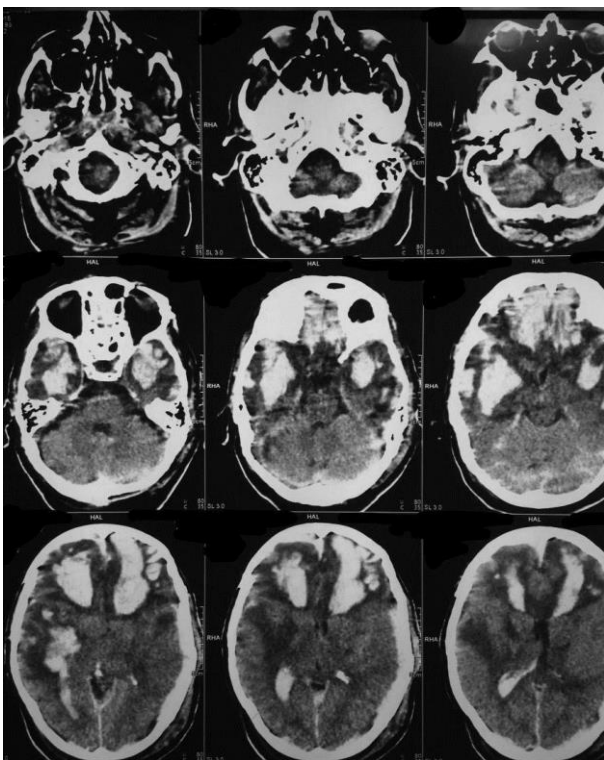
Follow-up CT scan showing marked changes with extensive intracerebral bleeding
